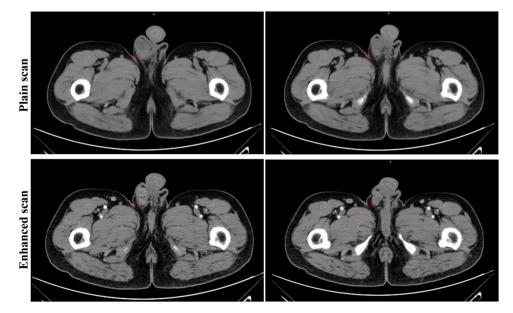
Pelvic CT shows poorly defined lesions (red arrow).
